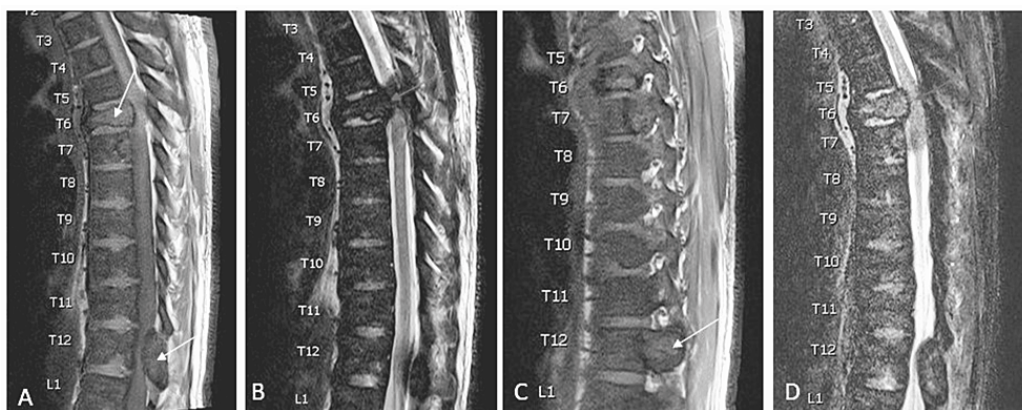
Sagittal T1 (A), T2 (B and C) and STAIR (D) MRI sequence of the thoracic spine showing diffuse abnormal bone marrow signal intensity with multilevel expansile osseous lesions involving the anterior and posterior column of the spine (white arrows). A pathological compression fracture of the T6 vertebra involving 40% of vertebral height is associated with retropulsion and contributes to spinal canal narrowing (red arrow in B). At the same level, the surrounding intraspinal CSF space is complete effacement associated with abnormal high T2 and STIR signal intensity within the spinal cord (red arrow in D).
